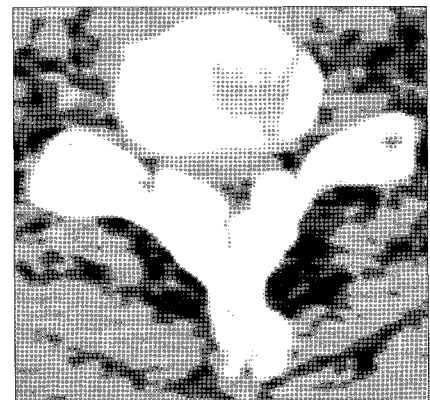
Axial computed tomography scan at C5-6 level shows an oval mass of high density projecting into the spinal canal and hypertrophic ligamentum flavum produced marked stenosis. The spinal cord is compressed severely.
